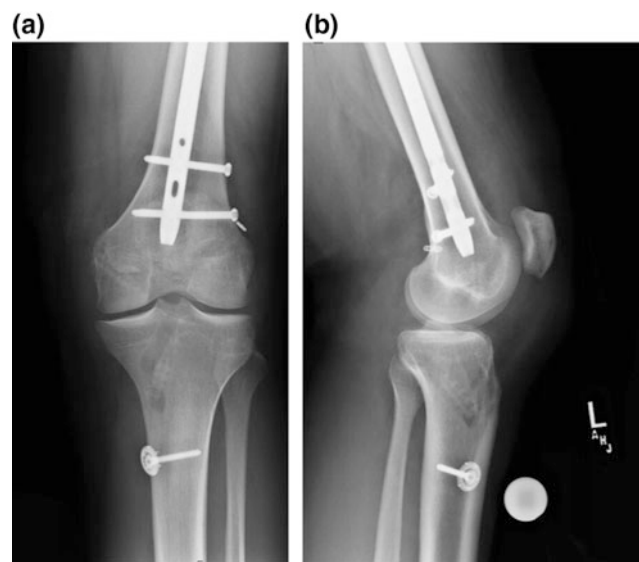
AP (a) and lateral (b) X-rays of a 19-year-old male patient with recurrent instability after failed MLKI reconstruction of the ACL and PCL. The patient had also undergone intramedullary rod fixation of a femoral shaft fracture following a motor vehicle collision
